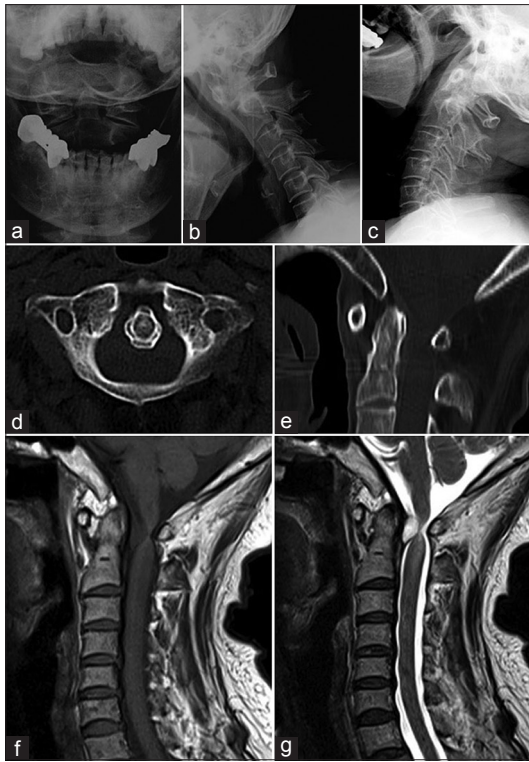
(a-c) Preoperative open-mouth anteroposterior radiograph and dynamic flexion and extension radiograph showing the atlantoaxial instability. (d and e) Preoperative computed tomography revealed an abnormality of the odontoid process. (f) The mass showed uniform low intensity on T1-weighted image. (g) The mass showed uniform high signal intensity on T2-weighted image
